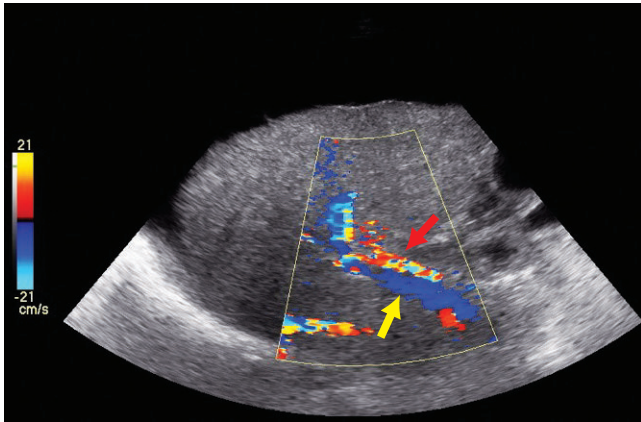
The color Doppler sonographic image of the liver shows hepatofugal flow in the right and main portal vein (yellow arrow) and aliasing in the hepatic artery (red arrow) indicating high velocities.
